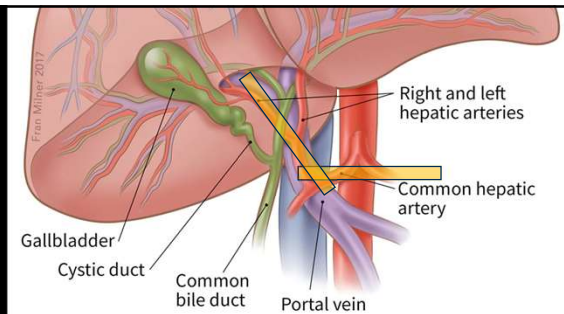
Hepatic circulation (a) and associated sonographic appearance, including the celiac axis, hepatic artery, splenic artery (b) and main portal vein (c).¹
